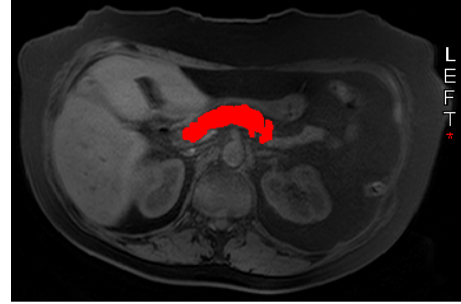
Manual identification of the pancreas region in one slice from a MRI volume.
